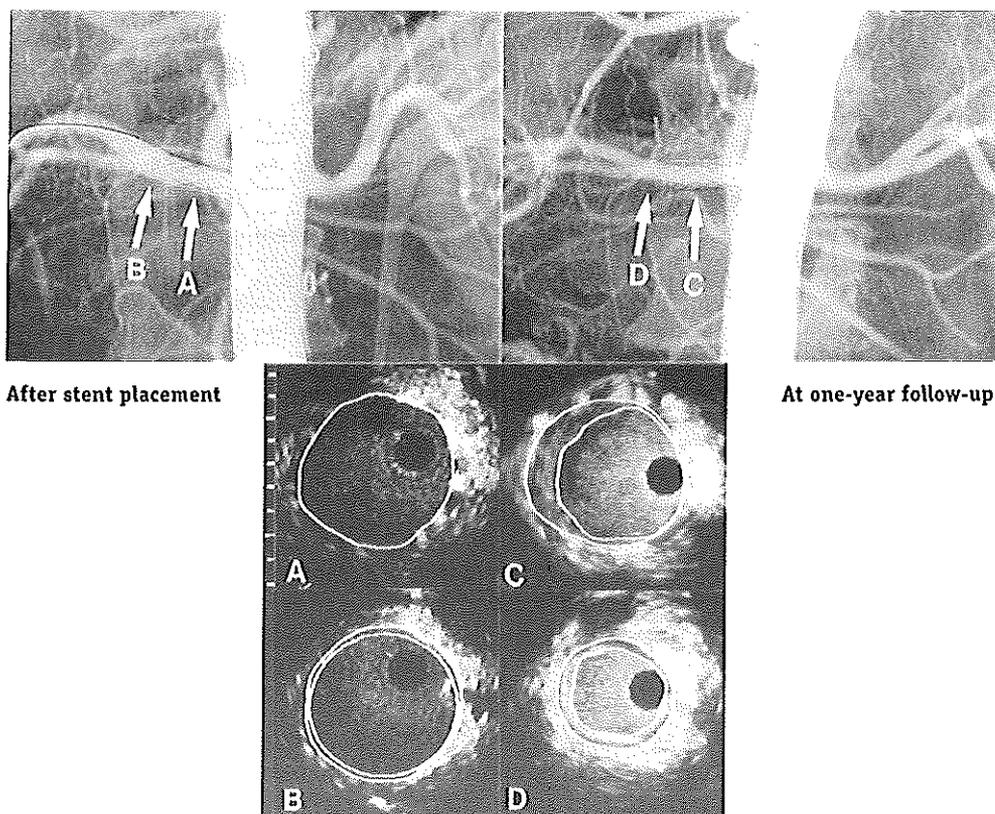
Intravascular ultrasound and angiographic images after stent placement (A and B) and at one-year follow-up (C and D). The inner contour of the intravascular images presents the lumen area; the outer contour the stent or vessel area. At follow-up plaque accumulation was evidenced in the stent (C) whereas the distal reference cross-section (D) showed shrinkage without plaque accumulation.
